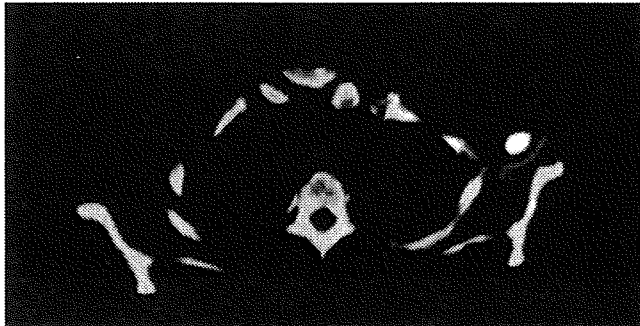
SPECT/CTによる左乳癌センチネルリンパ節マッピング
